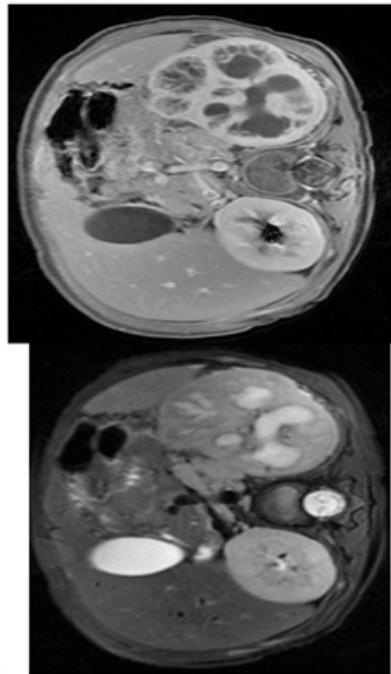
Left xanthogranulomatous pyelonephritis findings on MRI (Patient nº 4). It shows a diffuse increase in size of left kidney, with thinning of the parenchyma and multiple cystic images corresponding to dilated calyces and focal areas of parenchymal destruction that are heterogeneous in T2 sequence and low signal in T1.
